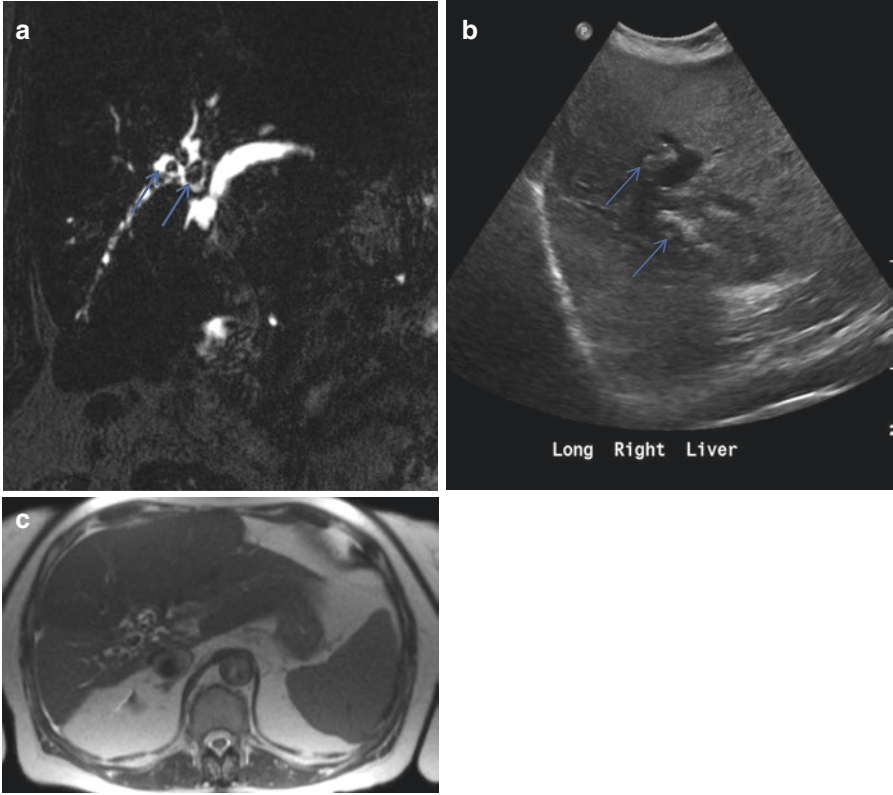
3D MRCP (a), ultrasound (b), and MRI (c) showing intraductal calculi in the same patient
